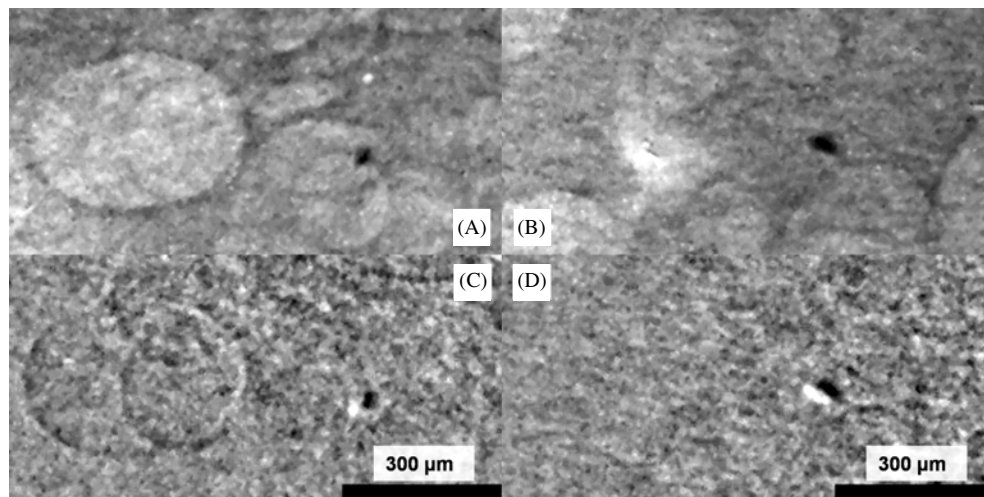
X-ray images of carbon enriched agarose objects embedded in chicken flesh: the round objects are fat bubbles in the chicken flesh. The entire sample is immersed in water. (A) and (B) conventional phase contrast images taken with a $25\ \mu\text{m}$ diameter x-ray source, and (C) and (D) corresponding ultrasound enhanced x-ray phase contrast image.
